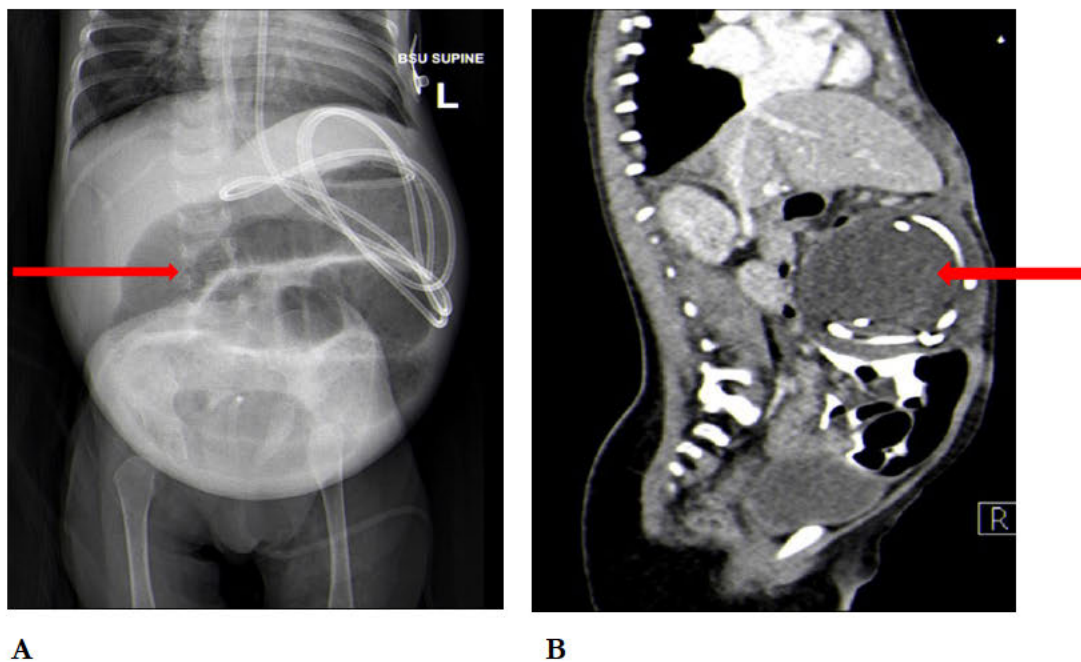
An abdominal X-ray (A) Shows Distension and Dilated Loops of Bowel in a Child with a Ventriculoperitoneal Shunt, Diagnosed with an Acute Abdomen. A CT scan of the Abdomen (B) Reveals a Shunt Within a Pseudocyst.
